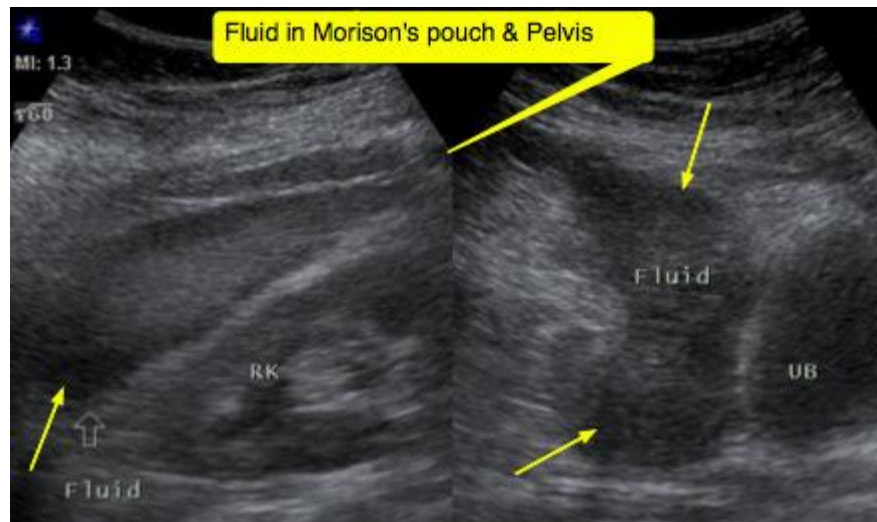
Ultrasound images showing free fluid in Morrison's pouch and Pelvis
